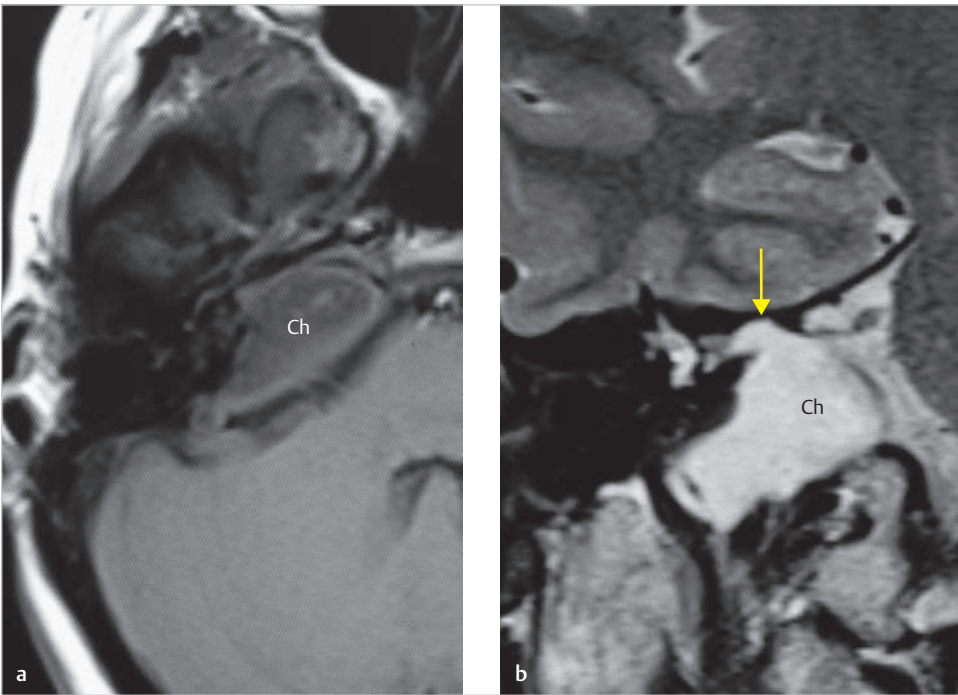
The lesion shows low in T1-weighted axial MRI image (a), and high signal in T2-weighted coronal image (b). Invagination of the cholesteatoma into the auditory canal is shown (arrow). Ch, cholesteatoma.
